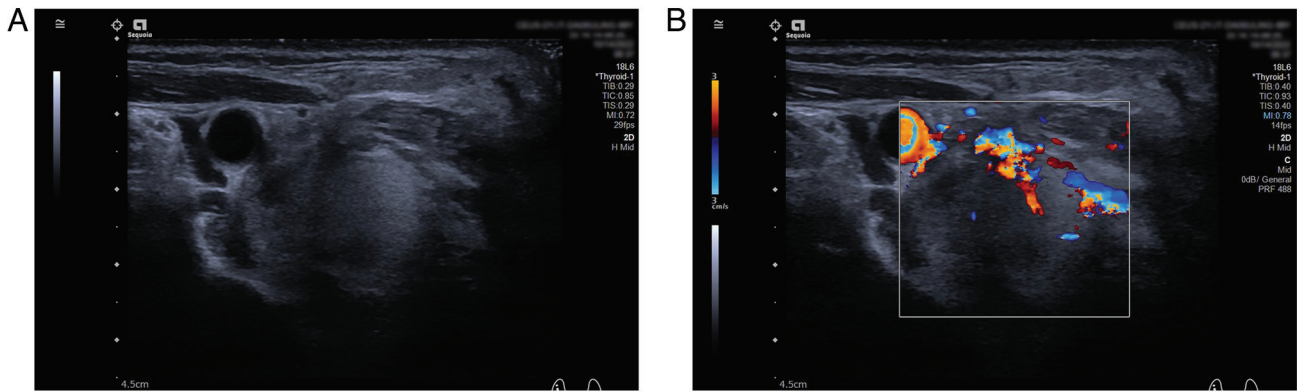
US and color Doppler findings of Lesion B before treatment. (A) US showed a solid slightly hyperechoic nodule with unclear boundaries. (B) Color Doppler flow imaging showed abundant blood flow signals in and around the nodule. US, ultrasound; CEUS, contrast-enhanced US; RI, resistive index; TIS, thermal index for soft tissue; TIB, thermal index for bone; TIC, thermal index for cranial bone; MI, mechanical index.
